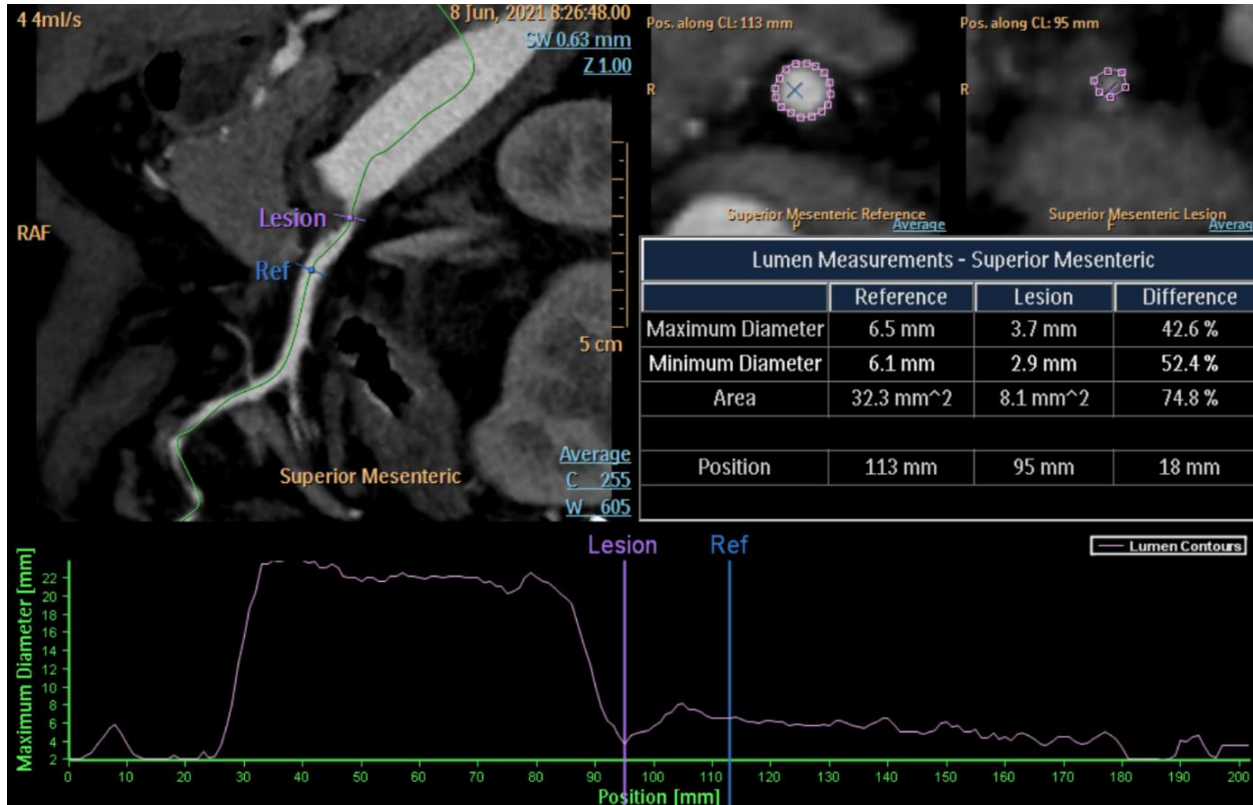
CT image showing the occlusion of superior mesenteric artery
